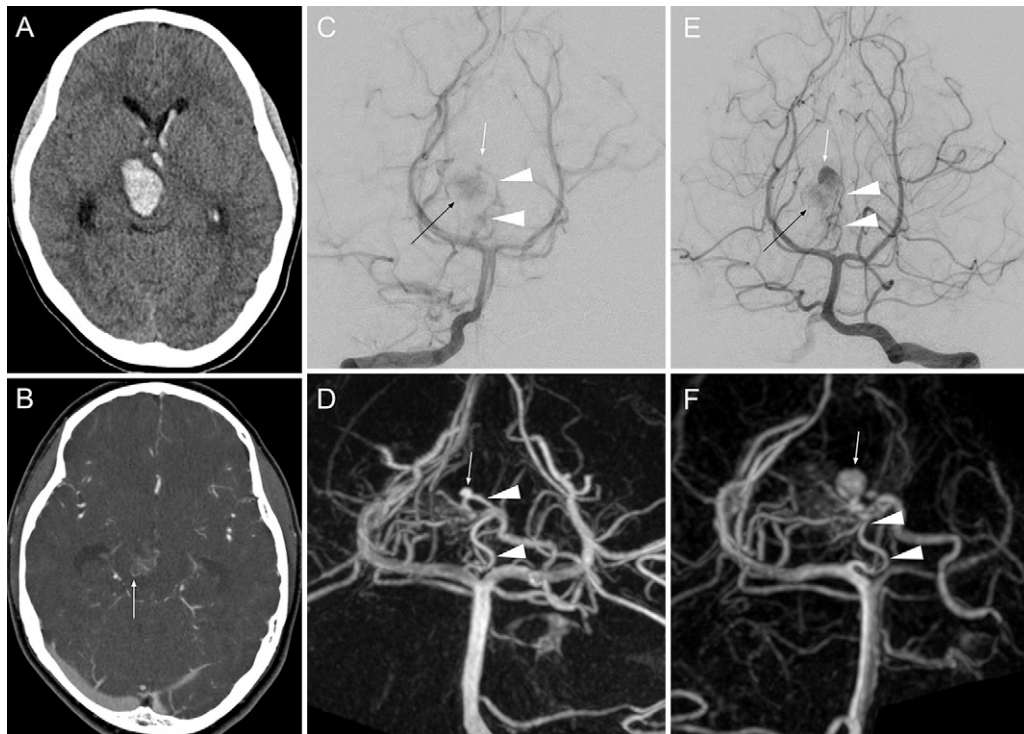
A: Noncontrast head computed tomography (CT) shows midbrain hemorrhage with intraventricular extension. B: Contrast-enhanced head CT shows a suspected AVM nidus (*white arrow*). C and D: Angiographic studies on day 1 showed an AVM (*black arrow*) fed by a right TPA (*white arrowheads*) with a small distal aneurysm (*white arrows*). E and F: Studies on day 29 showed the AVM (*black arrow*), feeder (*white arrowheads*), and increased aneurysm size (*white arrows*).
